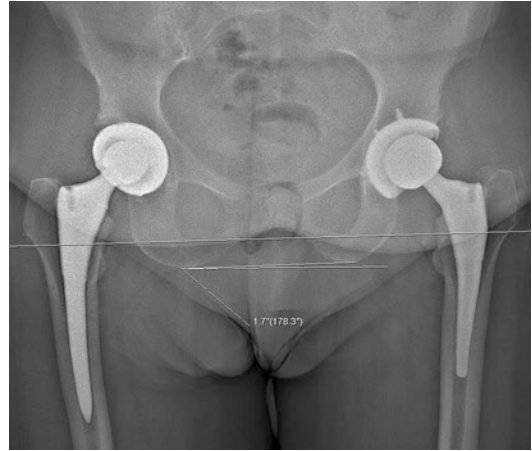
Postoperative standing AP EOS radiograph of the case example demonstrating leg-length equalization and near resolution of flexible pelvic obliquity at 4-week follow-up. Leg lengthening was planned with increased distance of femoral neck resection and increasing femoral LTC
